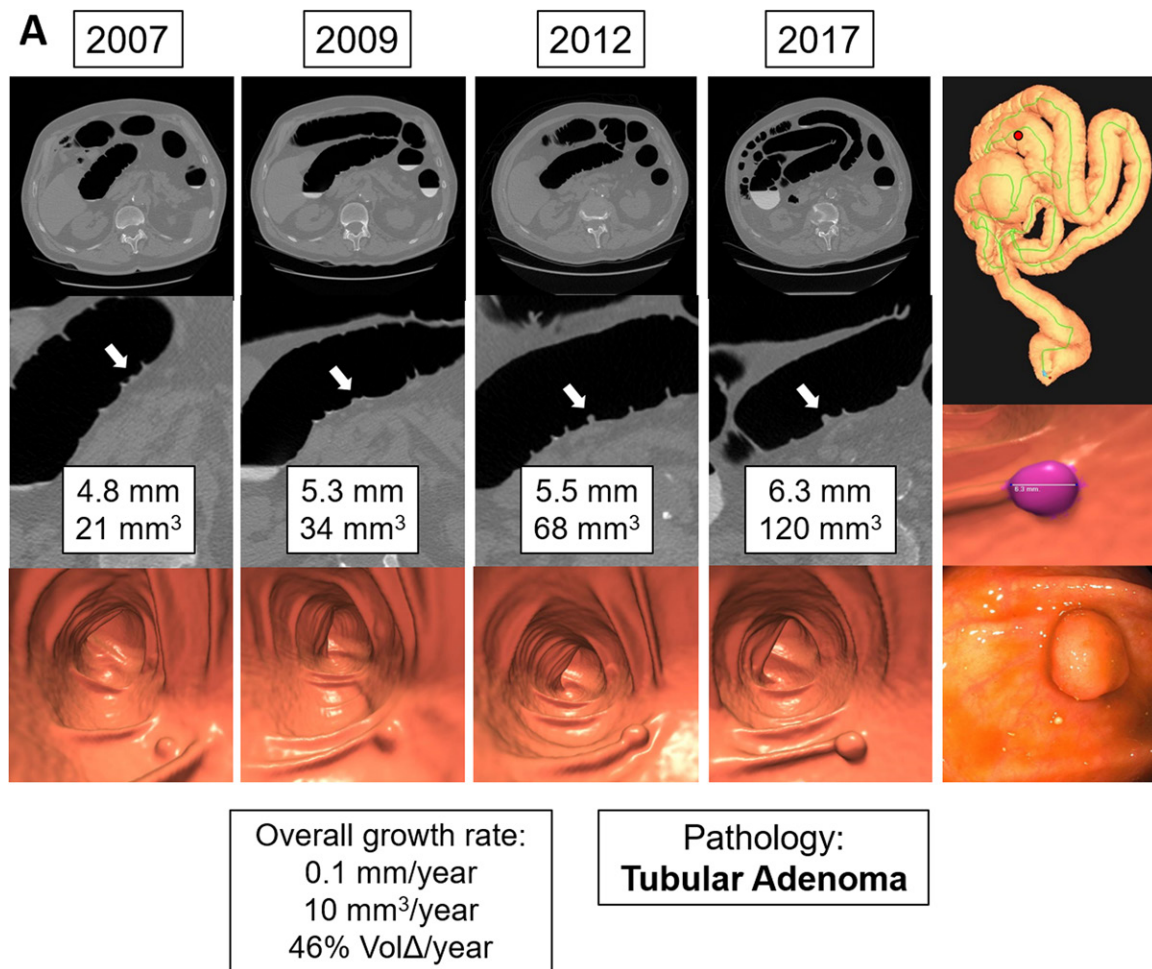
In vivo observation of two colorectal polyps over a decade in a man who was aged 71 years at initial CT colonography (CTC) in 2007. (A) Two-dimensional (top) and three-dimensional (bottom) CTC images show a subcentimeter sessile polyp (arrow) in the redundant right colon (red dot on colon map) monitored over four examinations. Images on the far right are the colon map (top), a three-dimensional CTC image showing semi-automated segmentation at CTC in 2017 (middle), and an endoscopic image from the time of resection in 2017 (bottom). The polyp was diminutive based on diameter until the final CTC examination, when it surpassed 6 mm. However, note the progressive increase in polyp volume, which increased sixfold despite only a minimal linear size increase. At endoscopic resection the polyp proved to be a tubular adenoma without high-grade dysplasia. (Fig 2 continues).
